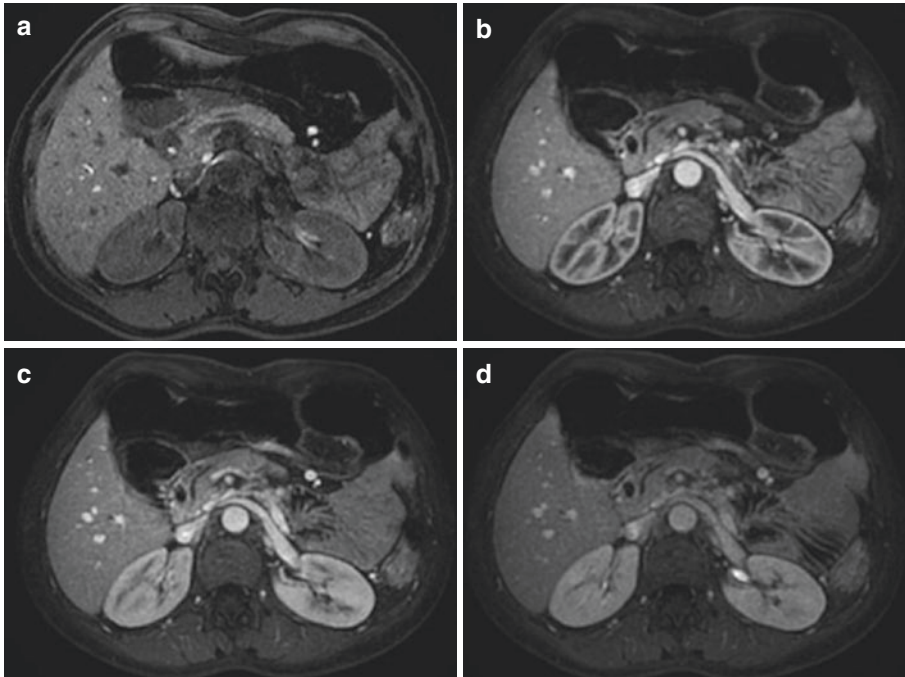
Dynamic MR imaging during contrast agent administration. (a) Axial fat-suppressed T1-weighted sequence before gadolinium chelate administration and during (b) arterial (40-s delay), (c) nephrographic (70-s delay) and (d) pyelographic (180-s delay) phases
